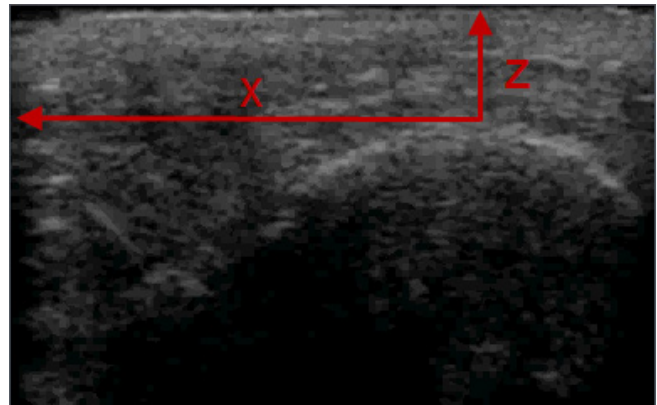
Ultrasound measurement of the Tibia with the transducer 2
